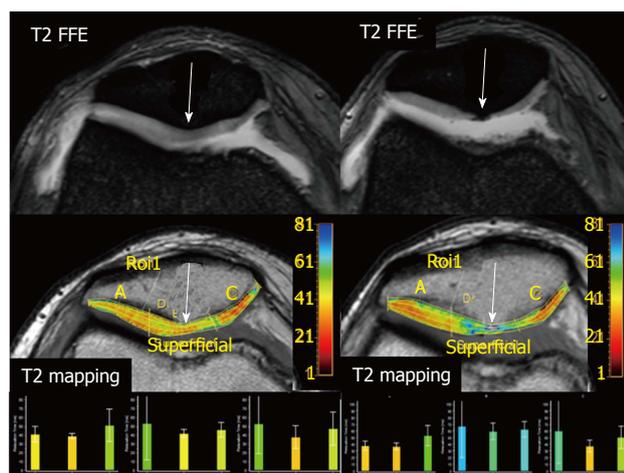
Osteoarthritis progression. A 49-year-old woman with knee pain is studied with two consecutive MRI studies. The first MRI (left images) shows a moderate joint effusion with patchy areas of increased signal intensity on T2 FFE sequence within the patellar cartilage. T2 mapping demonstrates diffuse increase in T2 relaxation times, more conspicuous at the patellar apex (arrows) consistent with early cartilage damage. Follow-up MRI performed 15 mo later (right images), demonstrates severe cartilage thinning, especially at patellar apex, that correlates with a severe increase in T2 relaxation times on the T2 mapping study. This clinical example demonstrates how T2 mapping can help to detect patients with evidence of early OA. MRI: Magnetic resonance imaging; OA: Osteoarthritis.
